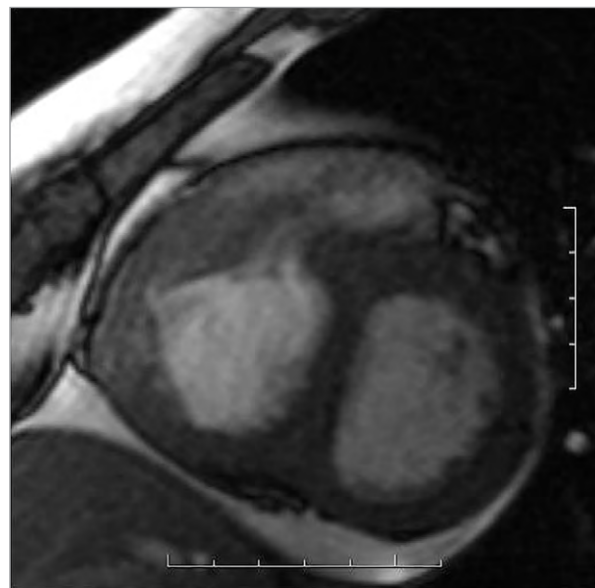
Magnetic resonance image confirms the presence of severe right ventricular outflow tract obstruction.
